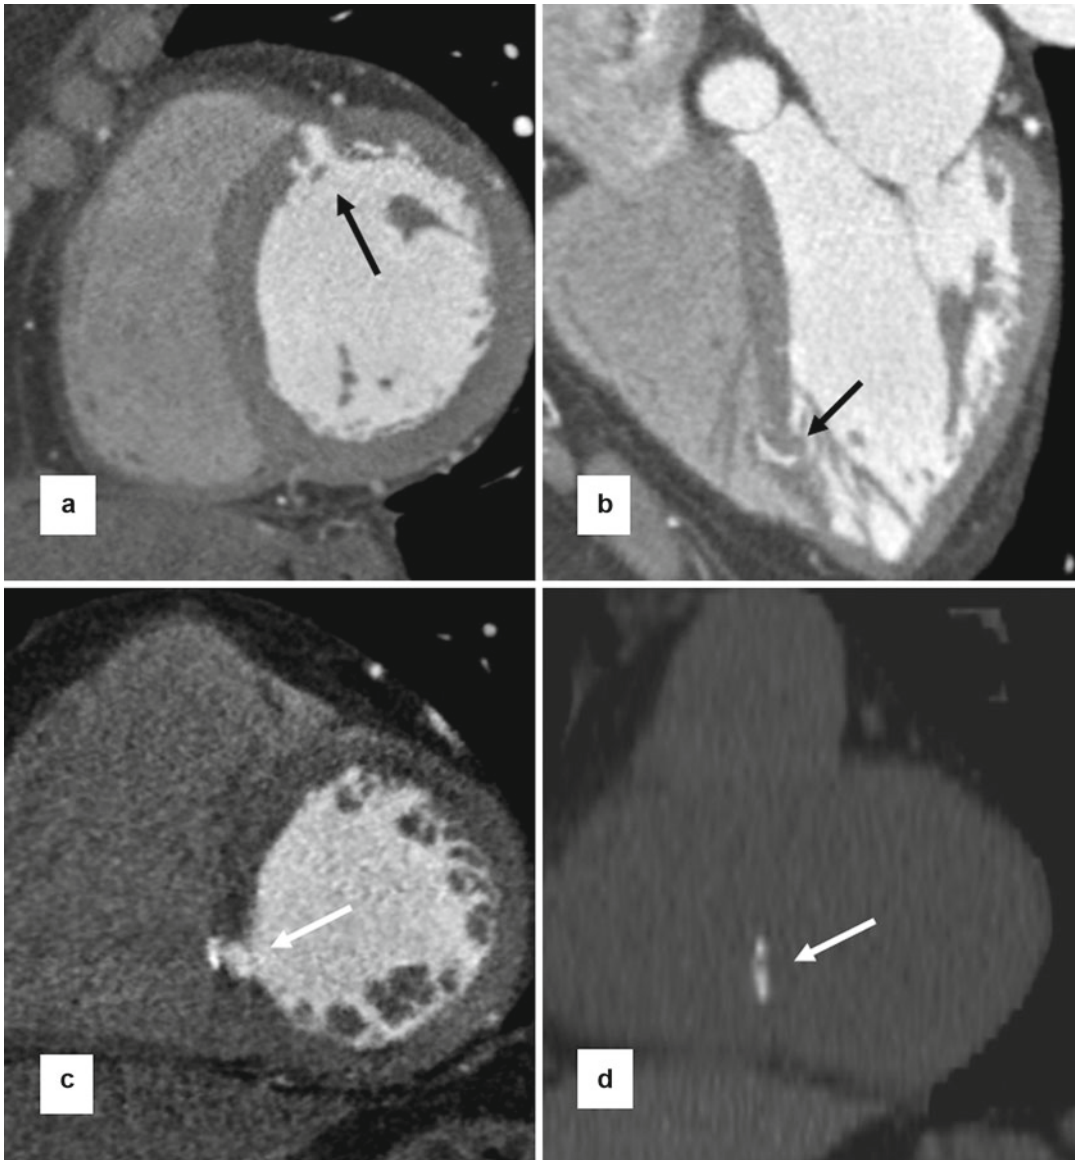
Left ventricular septum filling defects. (a) Short axis CT shows diverticular appearance of a large Thebesian sinus (*arrow*). (b) Large venous sinus (*arrow*)
